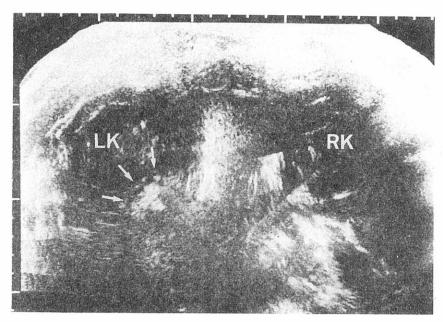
Posterior abdominal transverse contact-compound ultrasonography showed questionable evidence of a left suprarenal mass (white arrows) which seemed to have high echogenicity centrally.
